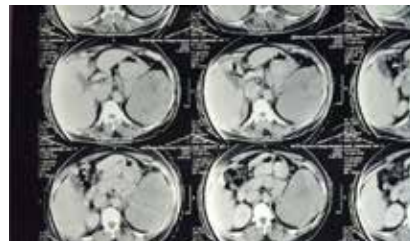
CT showing non enhancing hypodense lesion in midpolar region of spleen.
